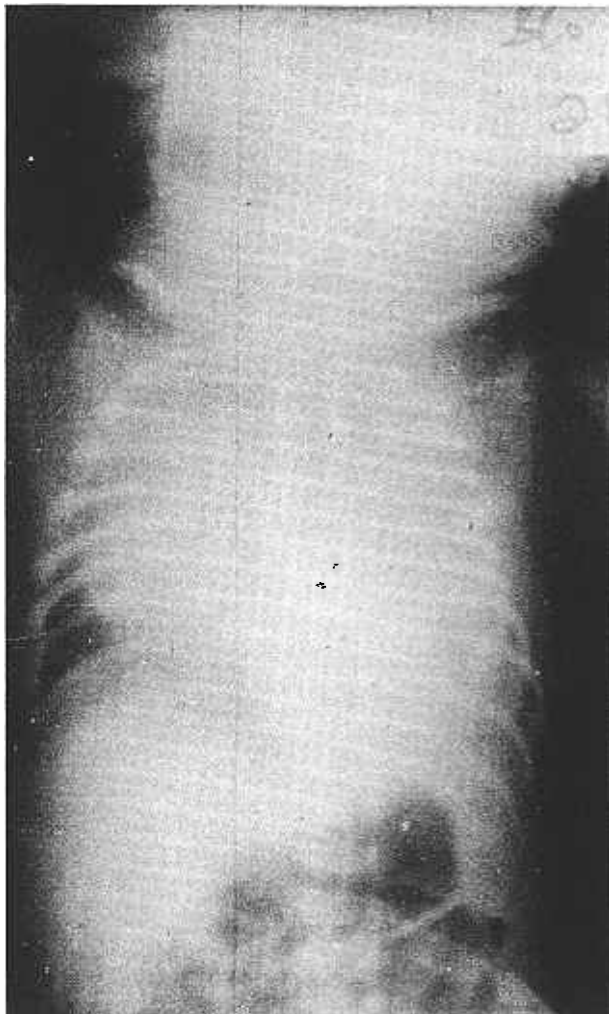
X-ray film showing opacification of the left hemithorax with a few radiolucent areas in the left mid-zone and displacement of the mediastinum to the right.
